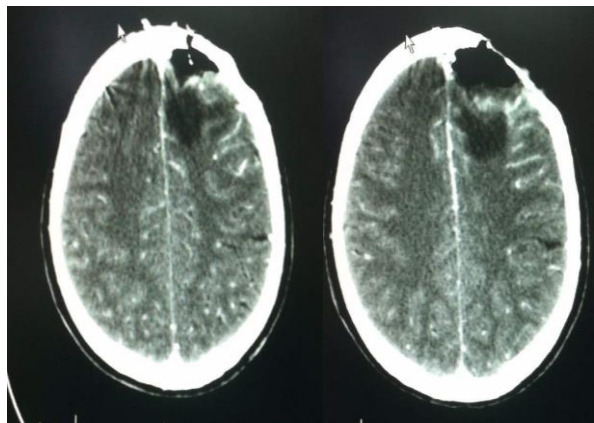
Postoperative Day 8 head CT shows postoperative changes with the left frontal craniectomy defect and resolving contusions in the left frontal lobe.
